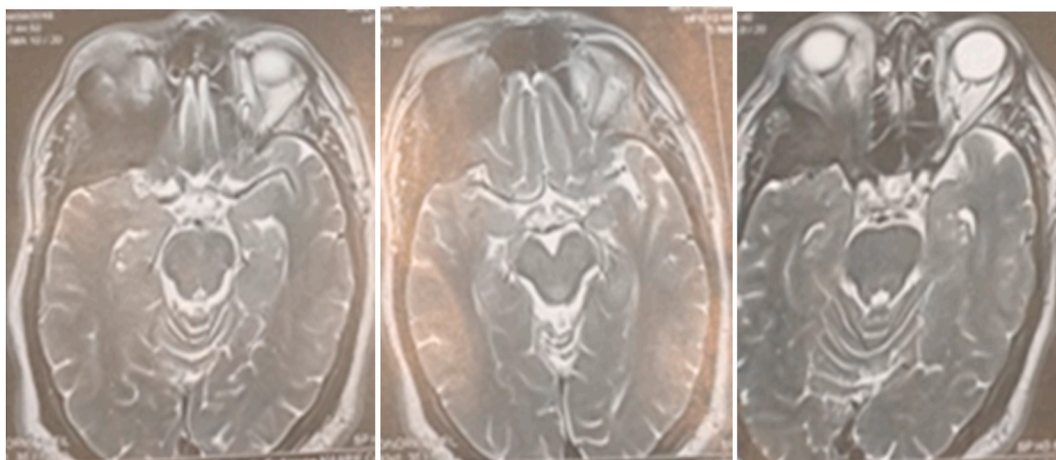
Crano-orbital MRI objectifying the spheno-orbital process.
